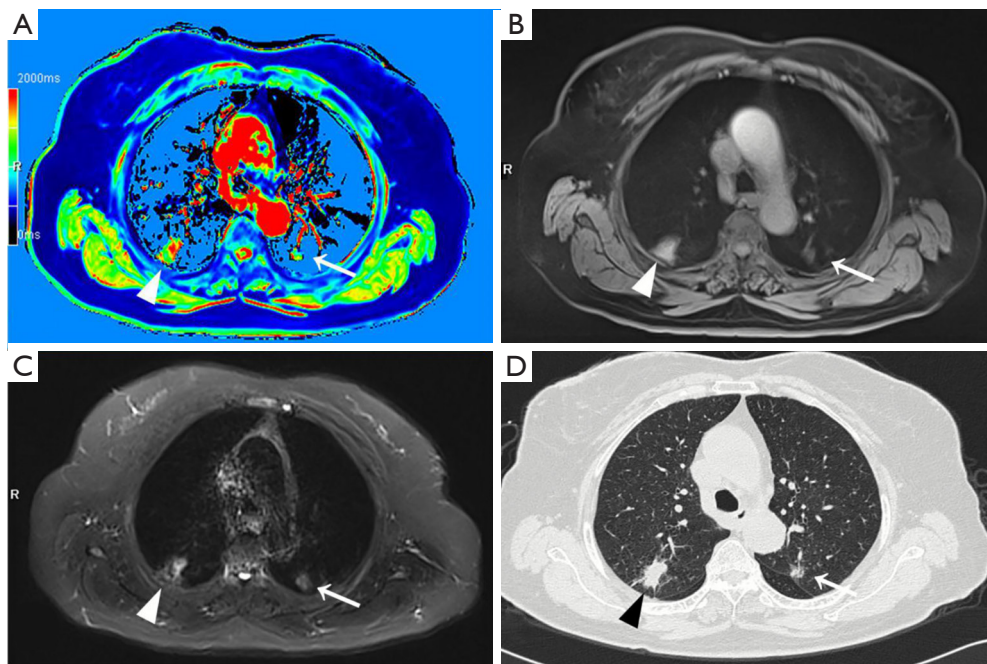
A patient with two simultaneous primary lung adenocarcinomas. (A) Native T1-mapping pseudocolor map; (B) T1-star VIBE; (C) T2-fBLADE; (D) computed tomography (CT; lung window). A nodule in the left superior lobe can be detected clearly by T1-mapping (A, white '→') while manifested as a part-solid nodule in CT (D, white '→'). The part-solid nodule was less intense in T1-star VIBE (B, white '→'), but more intense in T2-fBLADE TSE (C, white '→'). Another solid nodule, located in the right superior lobe (D, black '△'), can also be clearly detected by T1-mapping (A, white '△'). The nodule was slightly more intense in T1-star VIBE (B, white '△'), and markedly more intense in T2-fBLADE TSE (C, white '△'). VIBE, volumetric interpolated breath-hold examination; TSE, turbo-spin echo.
